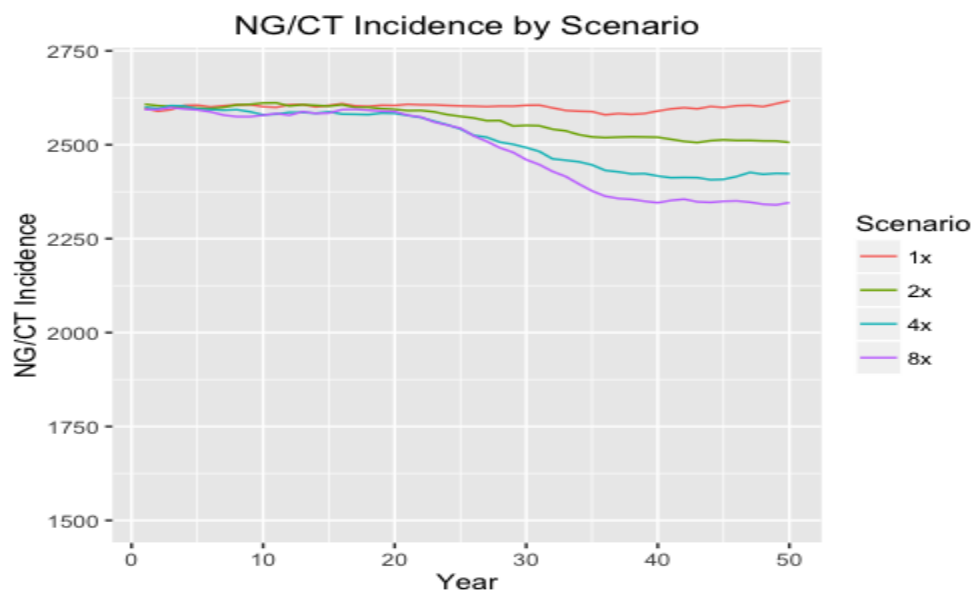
presents NG/CT incidence per 15,000 MSM for each year by scenario under the increased general HIV screening strategy
